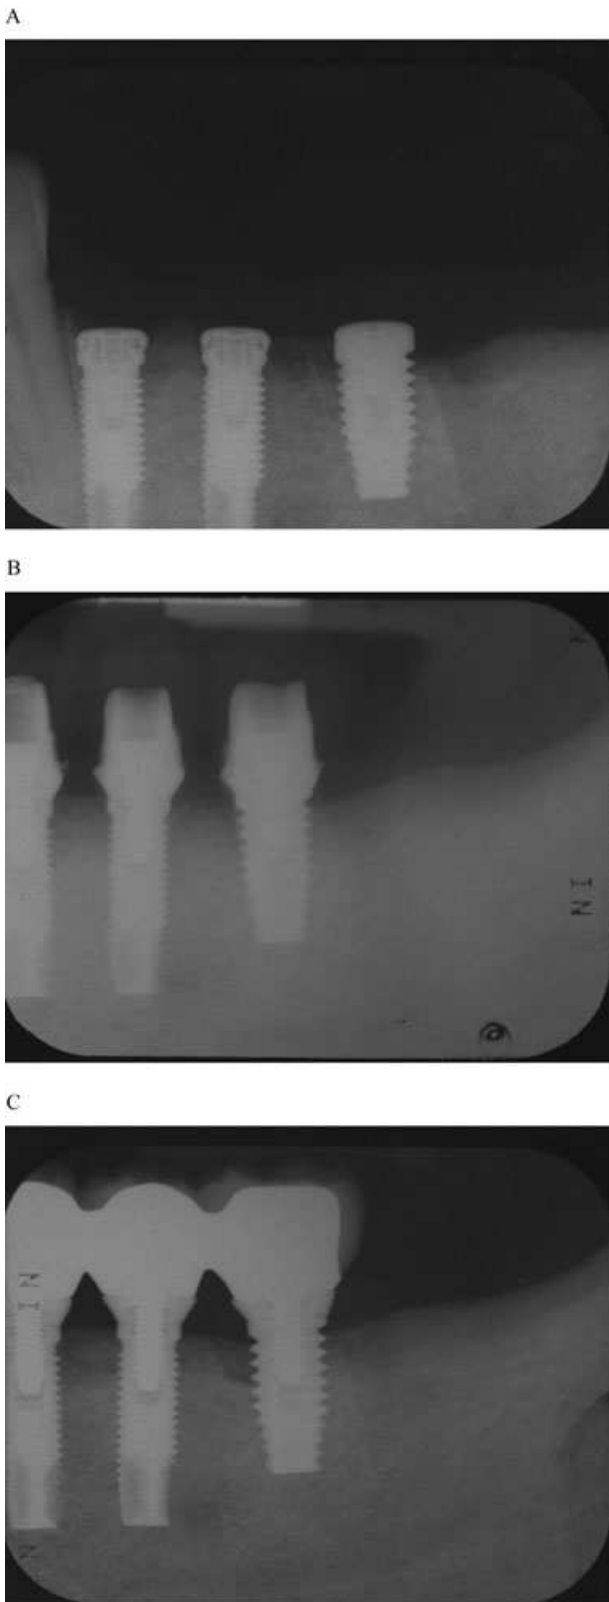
Radiographic aspect of ailing implants. (A) Postoperative radiograph at the time of implant placement. No peri-implant bone loss is present. (B) Postoperative radiograph at the time of abutment connection. No peri-implant bone loss is present. (C) Postoperative radiograph at 5 years. Peri-implant bone loss is extending beyond the third thread of the implant replacing tooth number 19.
